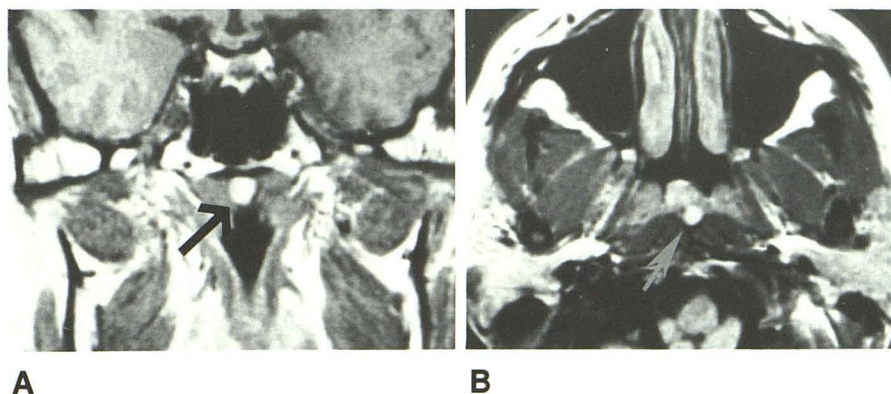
A-C, Sagittal (A), coronal (B), and transaxial (C) MR images show Thornwaldt cyst (arrows) as a round, high-signal midline lesion in nasopharyngeal vault on T1-weighted sequences. TR = 800 msec, TE = 20 msec at 1.5 T.
